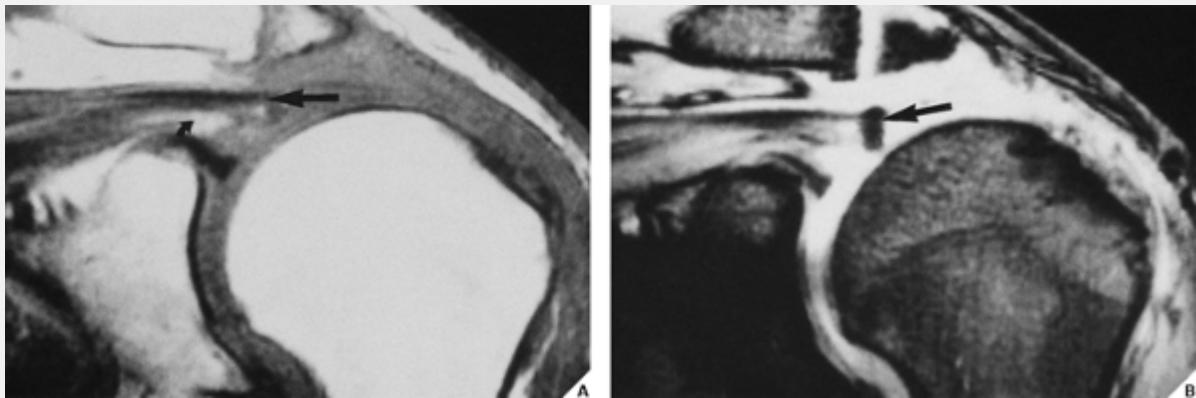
Full-thickness tear of the supraspinatus tendon. (A) Oblique coronal MR image of the left shoulder (multiplanar gradient-recalled T2\*-weighted) demonstrates interruption of the supraspinatus tendon and fluid in the subacromial–subdeltoid bursae complex, diagnostic of complete
